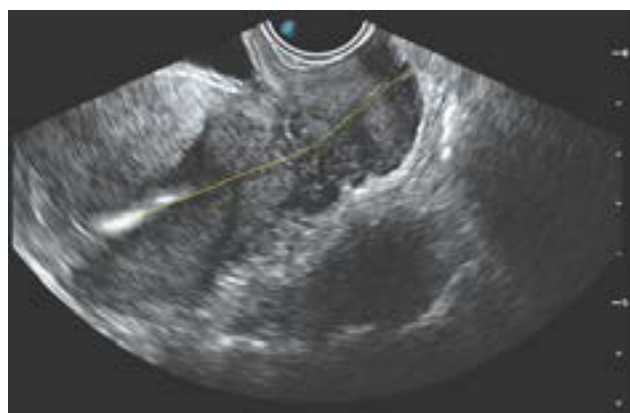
Woman with anteverted uterus. Ultrasound image shows cervix and body of uterus are at almost at same axis. Yellow lines show the flexion angle measurement between the uterine cervix and uterine corpus (168.7)
